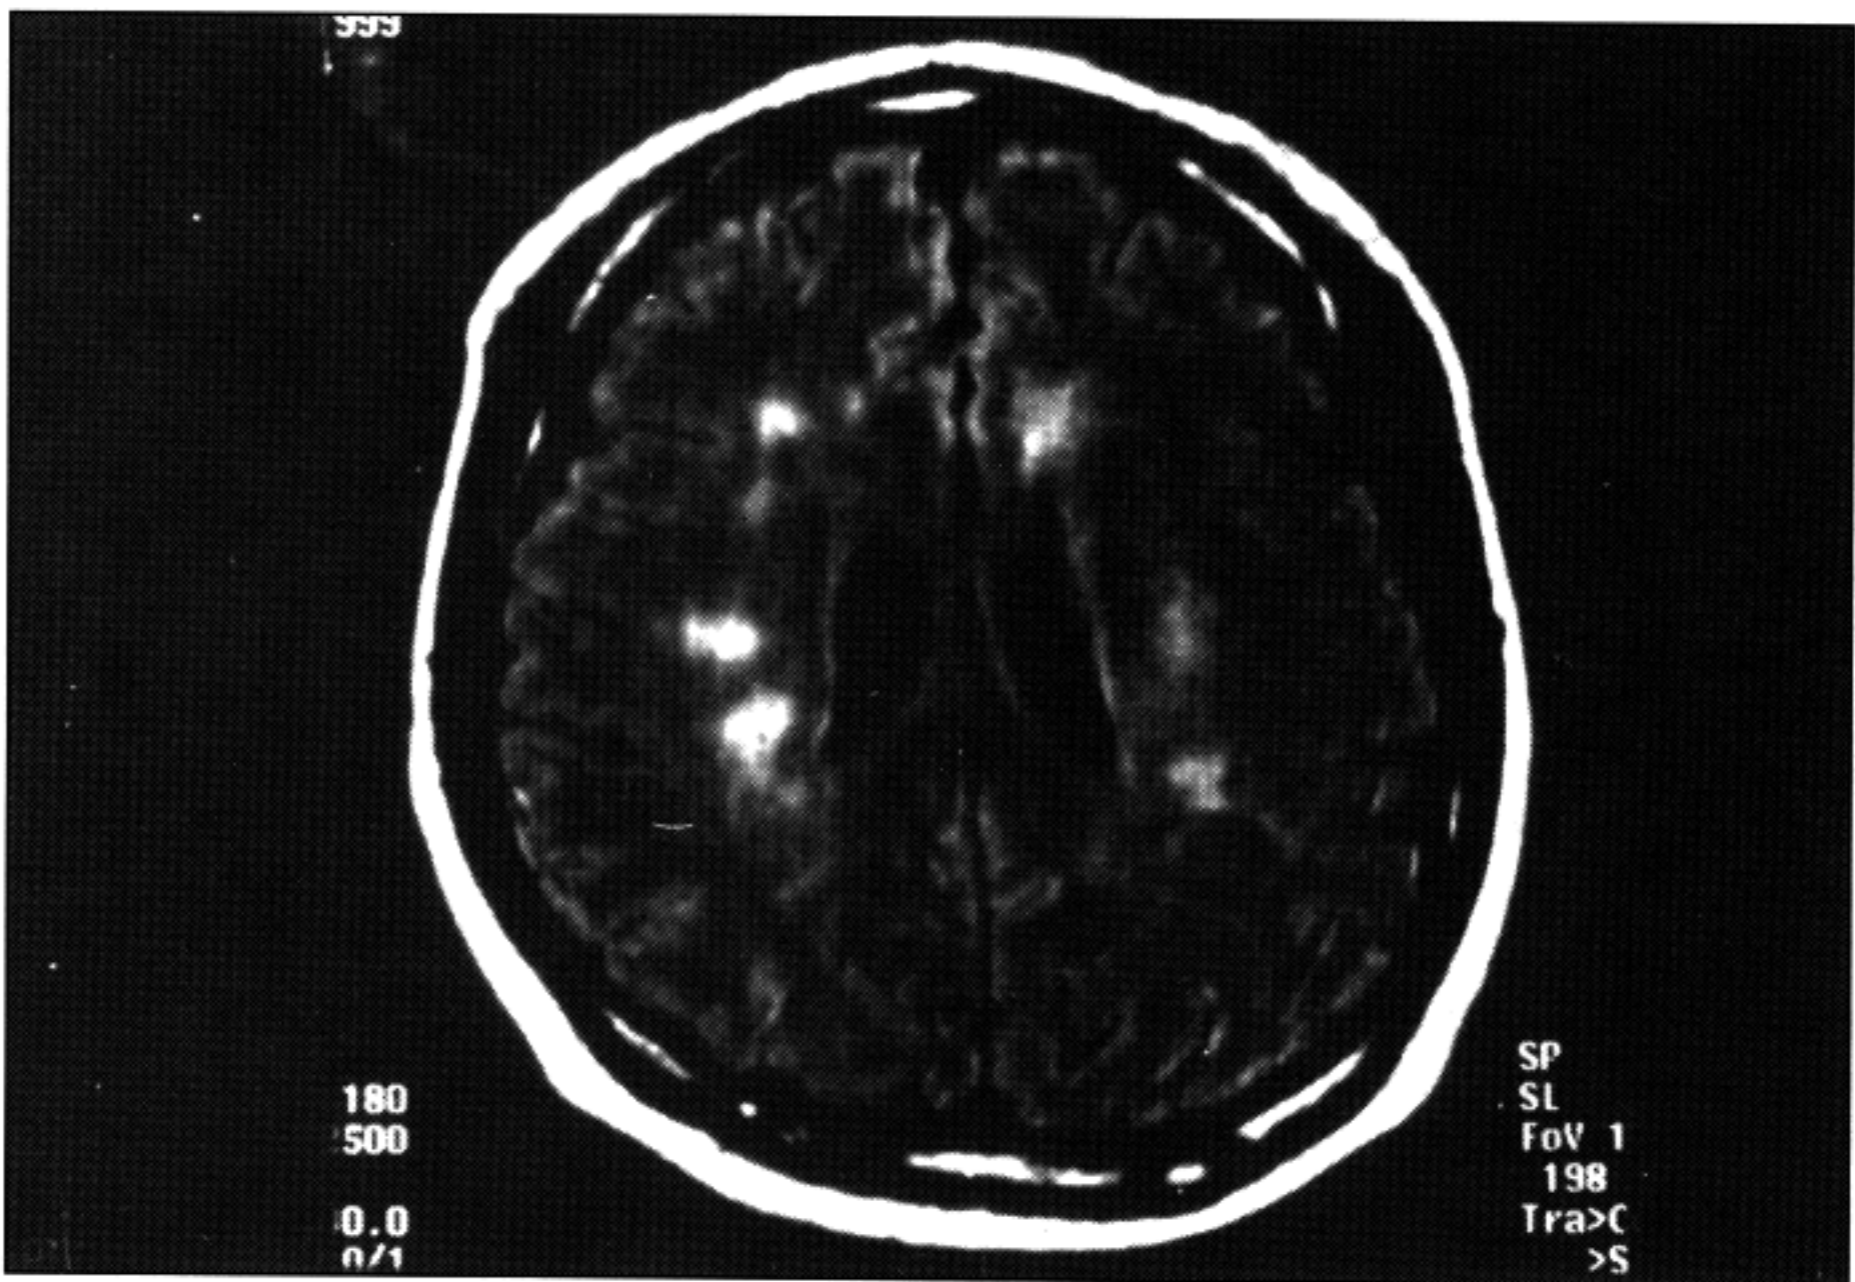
Axial MRI with fluid-attenuated inversion recovery (FLAIR) sequence showing multiple high intensity lesions in the left corpus callosum as well as in the deep white matter bilaterally.
